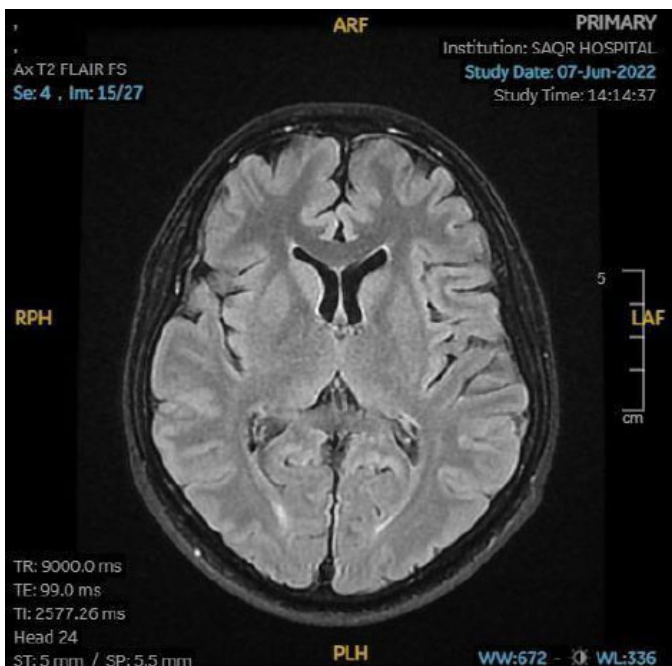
MRI brain w/o contrast result of the patient, showing small left choroidal fissure cyst, mild bilateral maxillary sinusitis with hypertrophied nasal turbinates. Otherwise, an unremarkable MRI examination of the brain.
